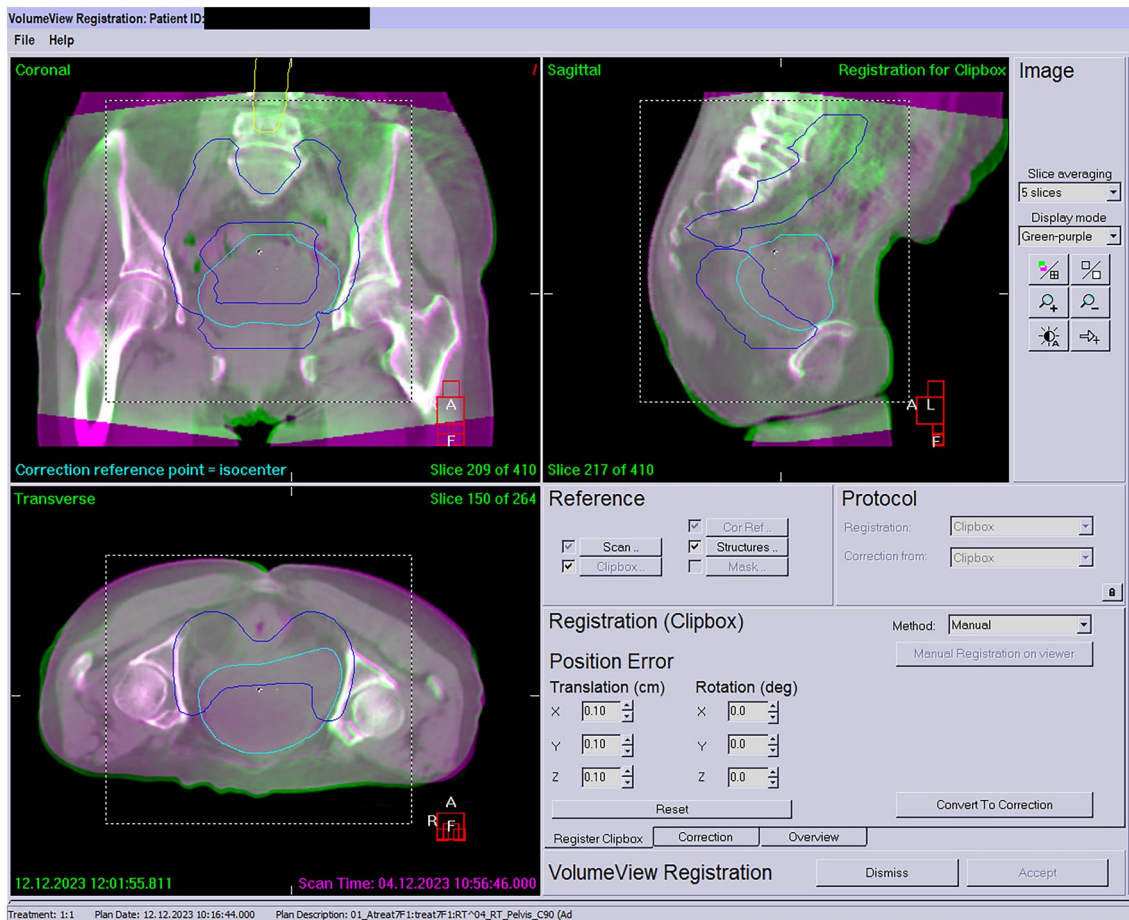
Measurement of setup errors using kV-CBCT
